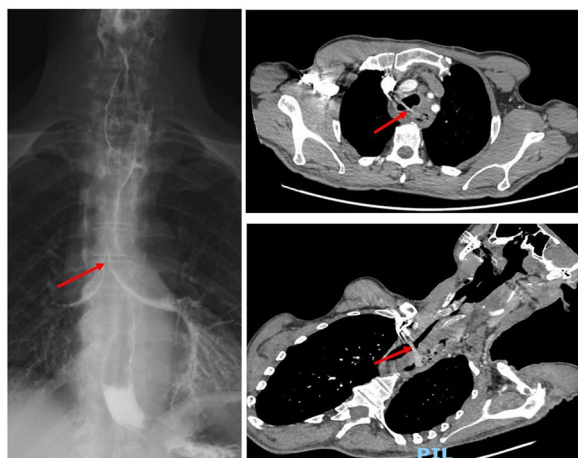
(abstract A262) Pre-operative barium swallow fluoroscopy study and CT imaging demonstrating linear hyperdense shadow extending from the oesophagus to proximal trachea causing fistulous communication.
